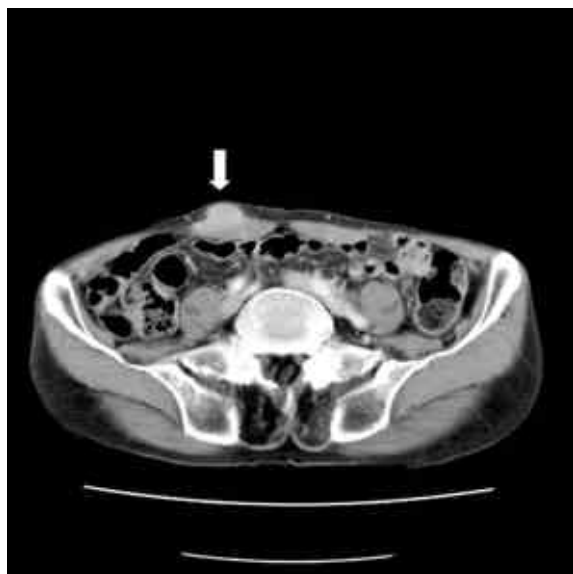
Computed tomography showing a subcutaneous, relatively high density mass (white arrow) due to the administration of leuporelin acetate 11.25 mg, mimicking a metastatic nodule.
